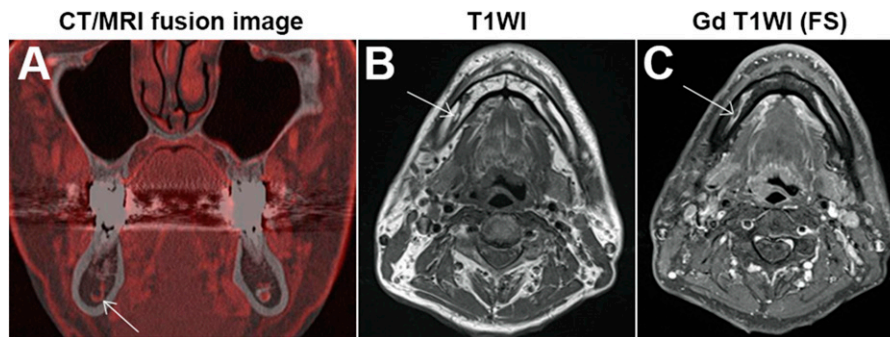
An example of the small pattern: (a) a coronal CT/MR fusion image showing the small pattern in the right molar (M) area. The pattern appears as a red hook in the mandibular canal (MC). (b) A T_1 weighted axial image showing a structure with high signal intensity within the MC. (c) An axial gadolinium (Gd)-enhanced T_1 weighted image (T1WI) with fat suppression (FS) showing an area of signal void within the enhanced course of the neurovascular bundles. These findings indicate that the area is composed of fat.
